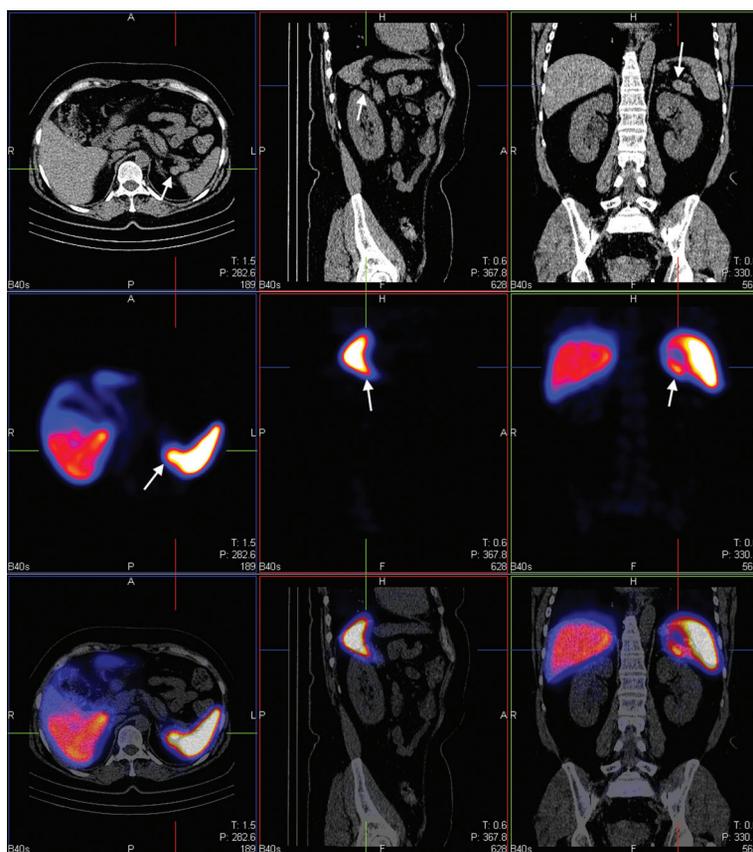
Patient 1. Similarly to Figure 2. In all single photon emission computed tomography scans activity from “main” and accessory spleen merges so the accessory spleen cannot be clearly identified. Fused functional-anatomical images make this identification much easier (arrow). Note also slight activity in the pelvicoliceal system coming from the radiotracer excreted with urine.
